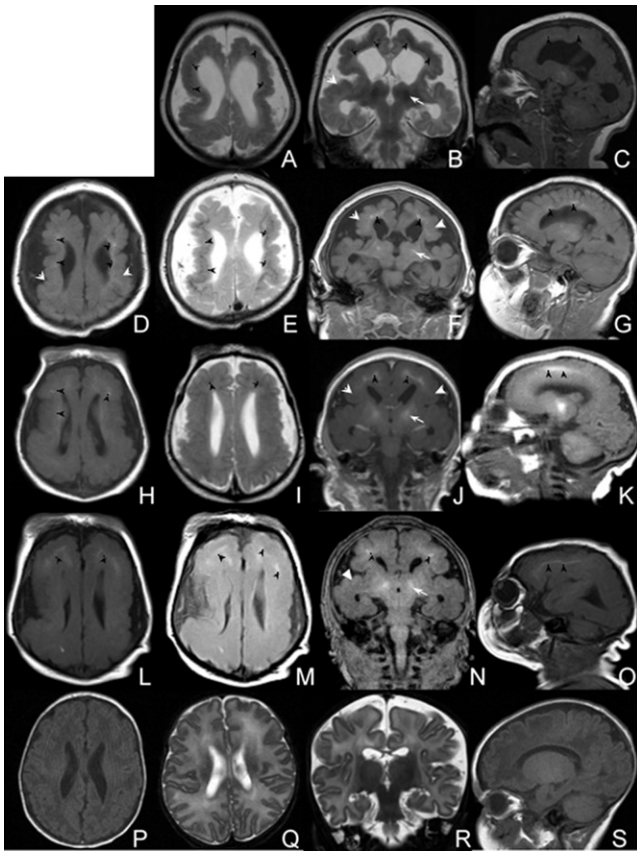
Selected MRI Images from Four Affected Individuals with BLC-PMG
